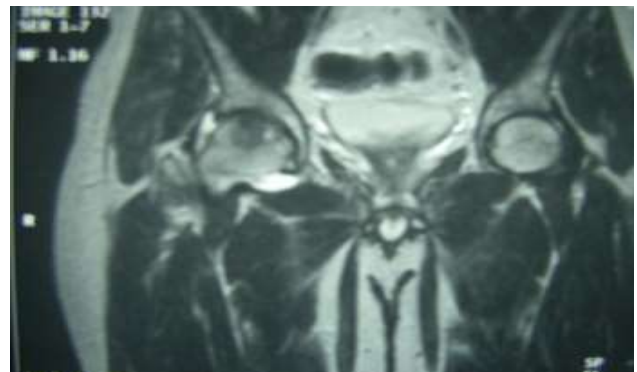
MRI showing AVN hip.
